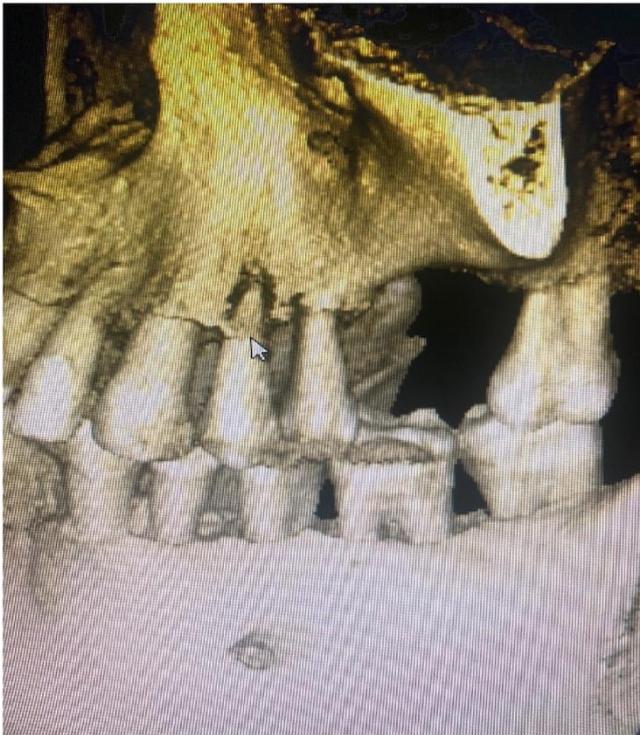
Intraoperative cone-beam computed tomography image.
